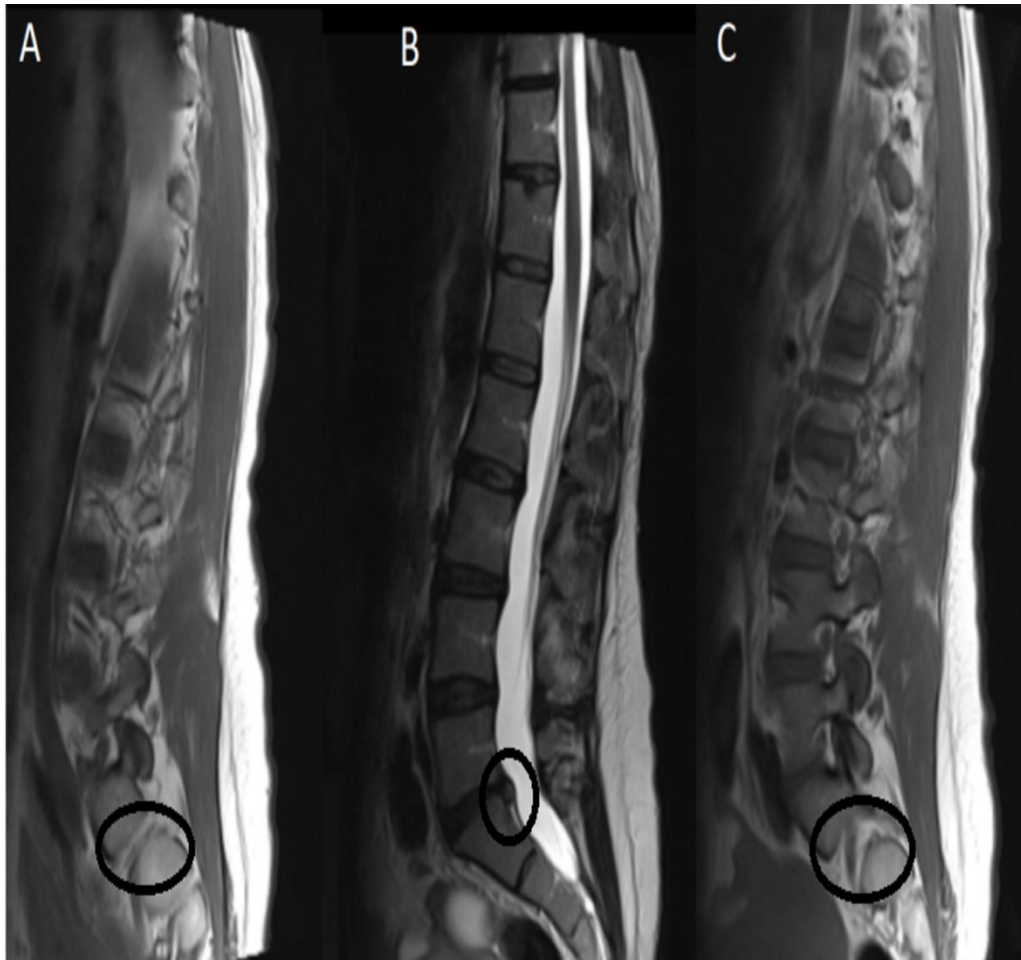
Lumbar MRI showing patent L5 foramen (T1 weighted images (A): right foramen, (C) left foramen) and Pfirman IV L5S1 disc degeneration ((B) T2 weighted images midline
